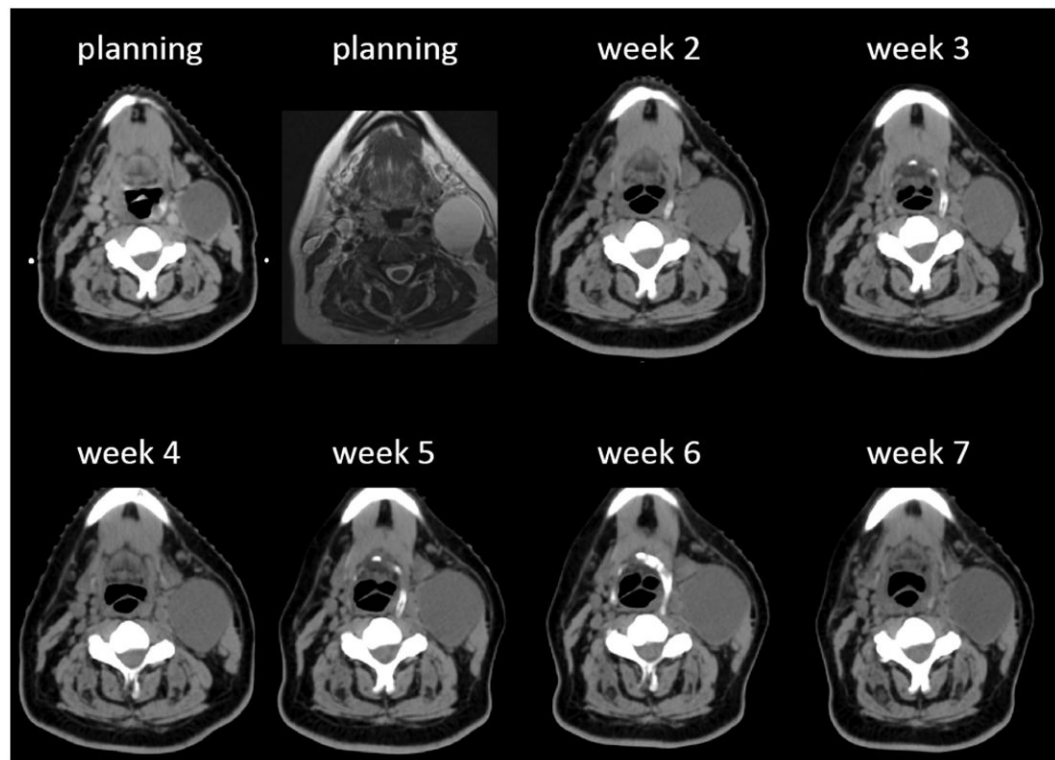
Planning/weekly CT scans and (T2W) MR images of a patient with a left level II to III cystic lymph node (LN). See text for explanation.
